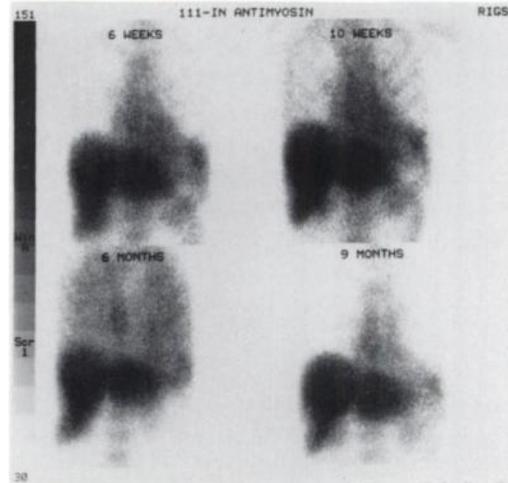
Antimyosin scintigrams 6 wk, 10 wk, 6 mo and 9 mo after heart transplantation in Patient 1 demonstrate increased diffuse uptake at 6 mo, where evidence of *Pneumocystis pneumonia* was present.
